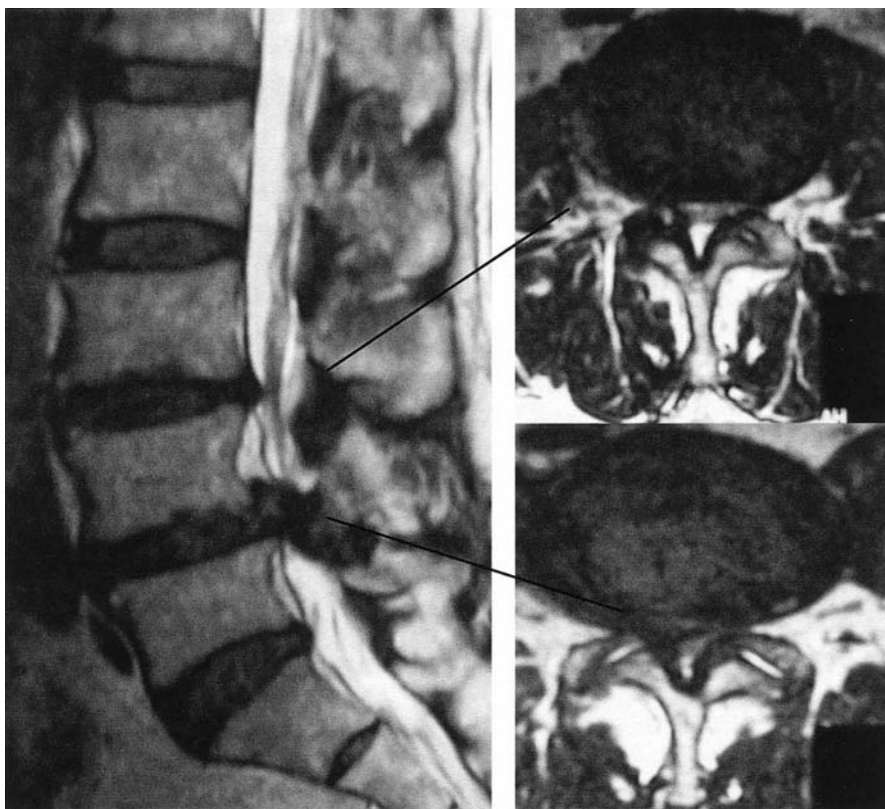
Magnetic resonance imaging (MRI) of 74-year-old man shows severe lumbar canal stenosis at L3-4, L4-5
